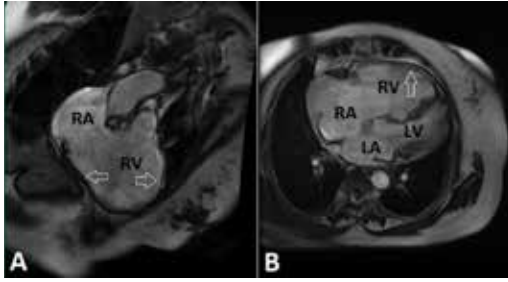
Cardiac magnetic resonance imaging steady-state free-precession (SSFP) images showed marked dilatation of the right atrium and the right ventricle with the complete absence of the right ventricular myocardial layer (white arrows)
